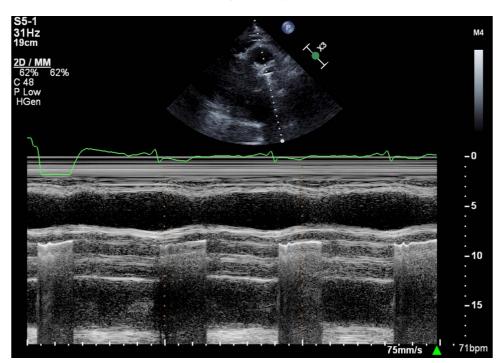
M-mode parasternal long axis through the AV.
